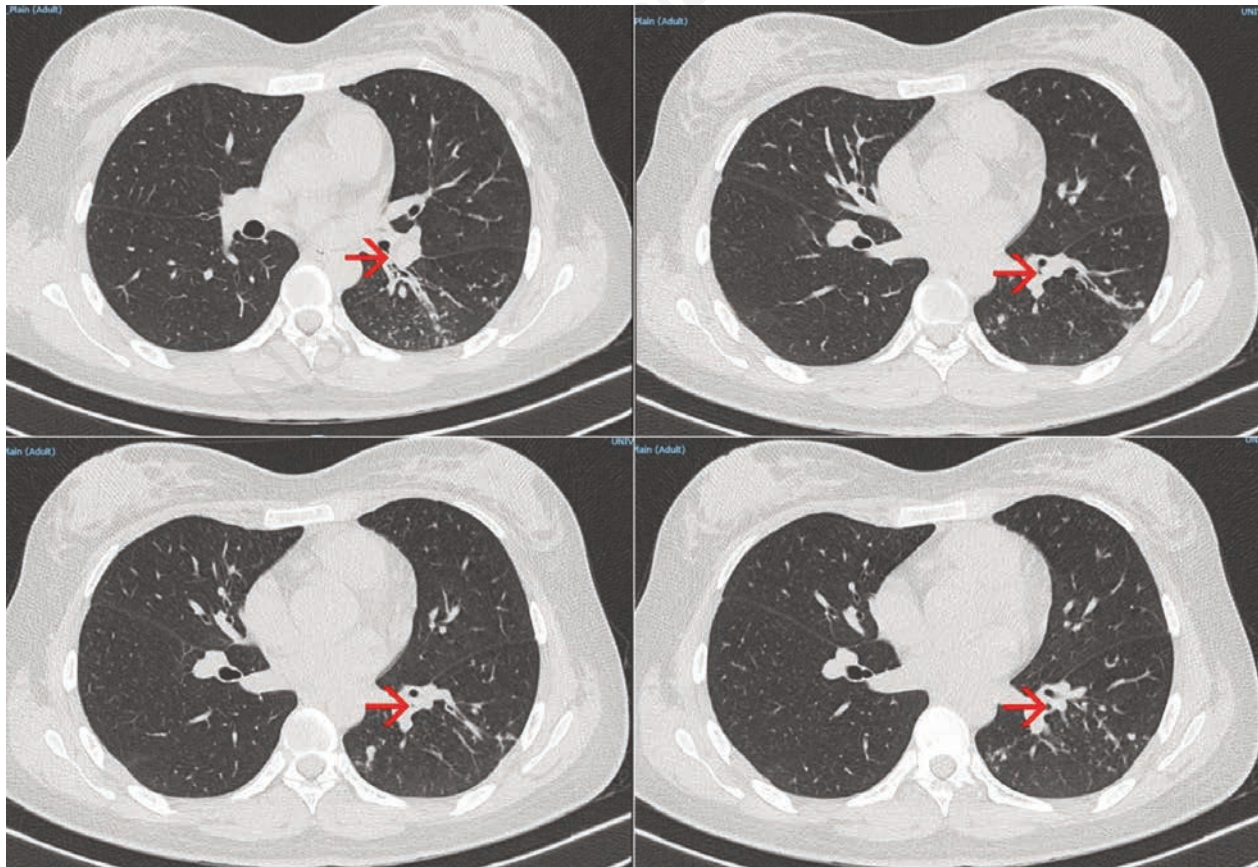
Chest computed tomography scan showed “tree-in-bud” pattern in the superior segment of the left lower lobe. Narrowing of the left lower lobe segmental bronchi is also indicated (red arrows).
